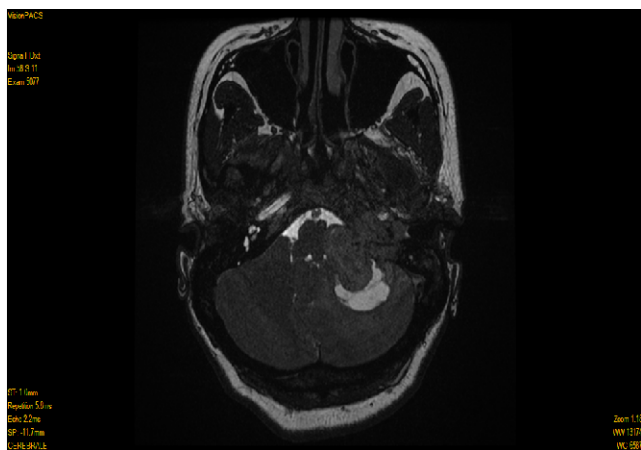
MRI brain with contrast; T2 coronal sequence revealing a mass in the region of left jugular foramen, extending into the tympanic cavity, mastoid cells and cerebellopontine angle.
